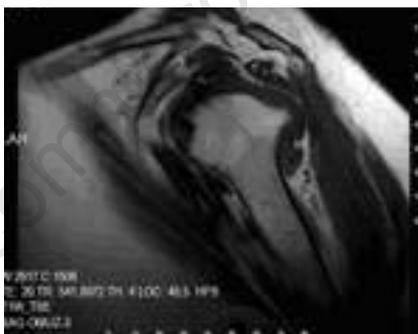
Severe degenerative changes with narrowing of the right shoulder joint space on magnetic resonance imaging of the right shoulder.
